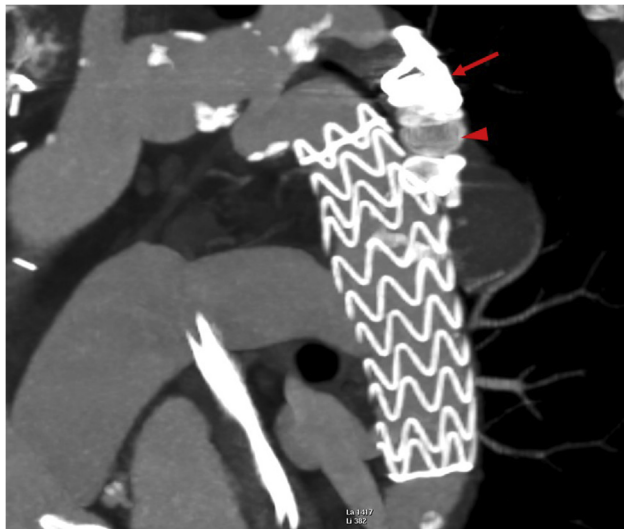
Postoperative computed tomography (CT) reconstruction showing Penumbra packing coils (Penumbra, Inc; arrow) positioned in the subclavian–aortic bypass upstream from the previously placed plug (arrowhead) with complete exclusion of the anastomotic aneurysm.
